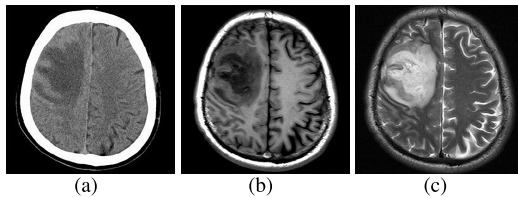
The comparison of CT images and MRI images of the brain. The brain CT images (Fig A) showed the hypodensity of the right frontal lobe of the brain and the T1 and T2 weighted MRI images (Fig B and C) also showed the hypointensity of the lesion with less noise and gives better image representation.
